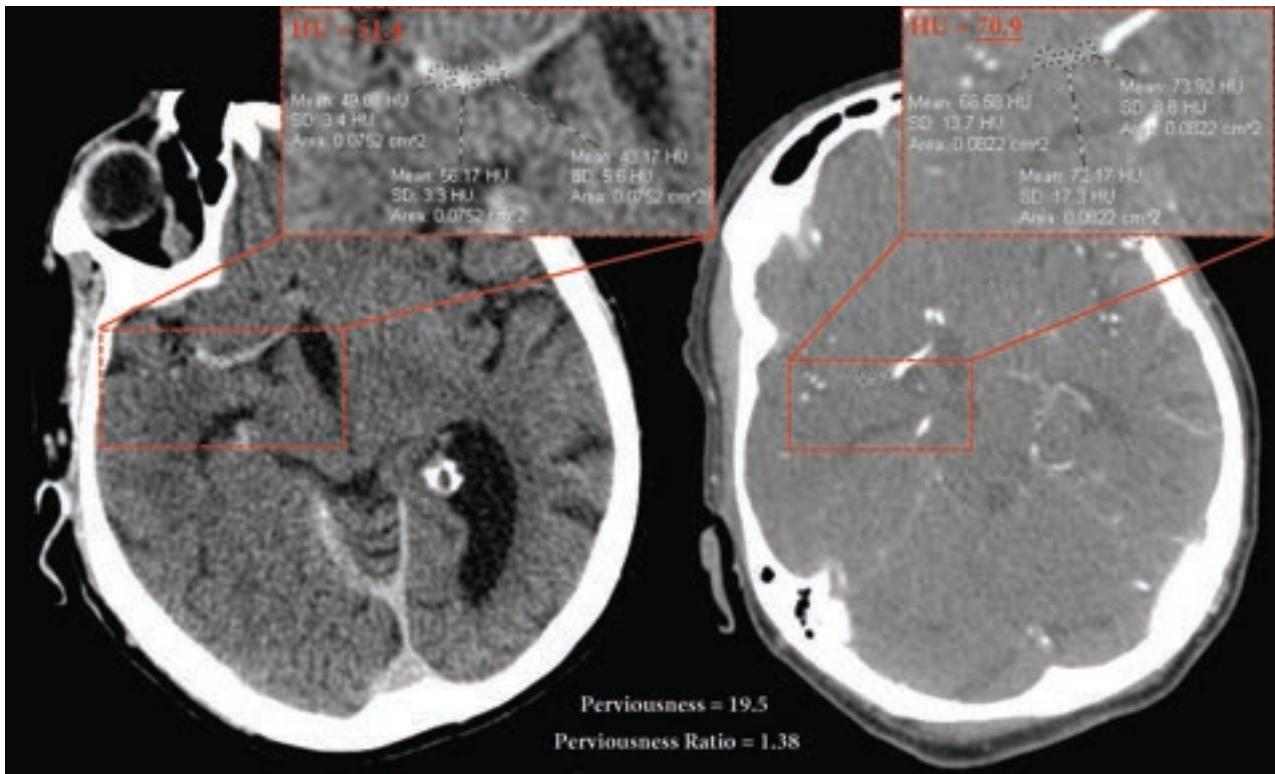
Sample calculation of thrombus perviousness/permeability on admission NCCT (*left*) and CTA (*right*). The image on the left demonstrates NCCT with 3 ROIs placed on the thrombus, with the thrombus attenuation in Hounsfield units calculated as the mean among the ROI values. The image on the right demonstrates a similar thrombus attenuation calculation on CTA. Perviousness was then calculated as the difference in Hounsfield units between CTA and NCCT. Likewise, the perviousness ratio was calculated as the ratio of Hounsfield units of the CTA over NCCT.
